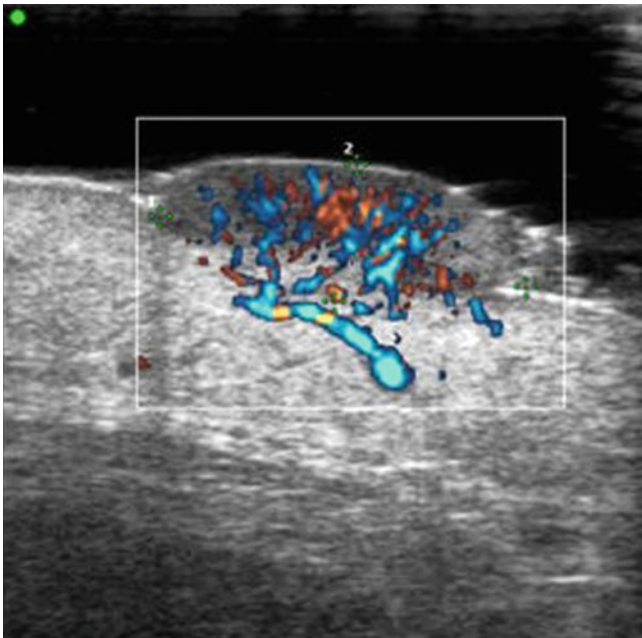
Melanoma, primary tumor on the calf. Directional power Doppler image. Because of the prominent shape a gel stand-off pad was used. Note the already marked perfusion
